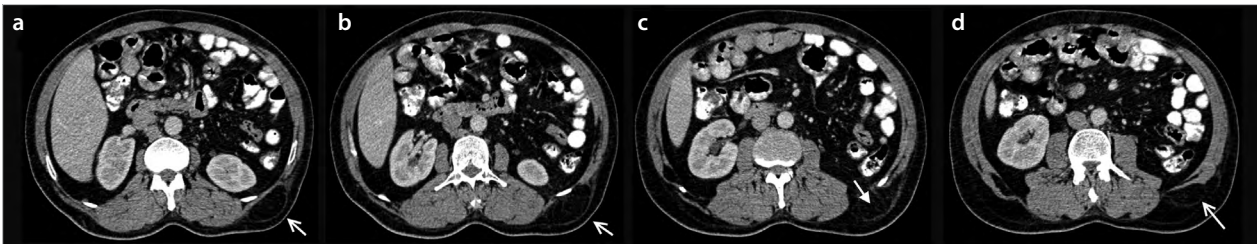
a-d. CT scan of the patient showing a herniated mass extending from the abdomen to the left posterolateral abdominal wall. Four CT images with 1.5-cm intervals starting from (a) to (d). White arrows in (a, b, d) show hernia. Full white arrow in (c) shows herniation through the lumbar area
